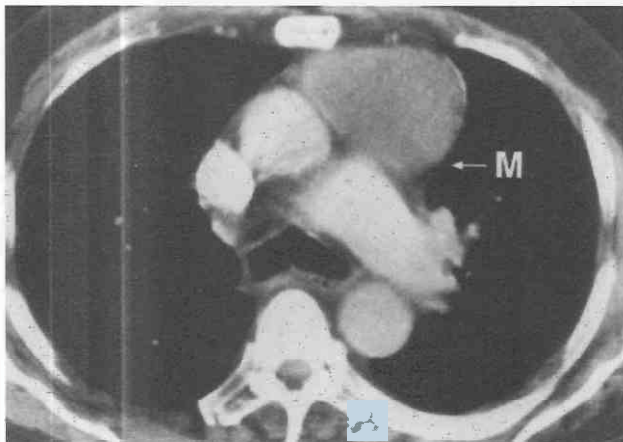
Thymoma. Contrast-enhanced CT shows large anterior mediastinal mass (M) anterior to aorta and pulmonary artery. Main pulmonary artery is displaced posteriorly.
